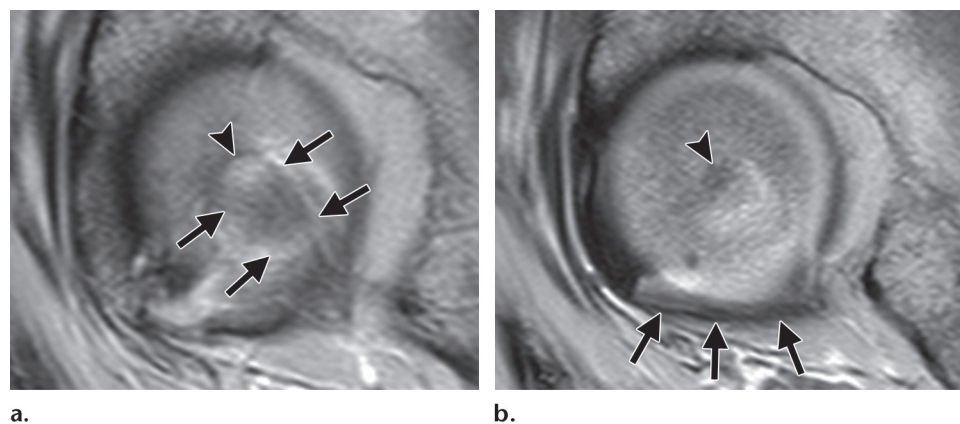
Consecutive sagittal T1-weighted MR arthrograms show the ligamentum teres (arrows in a), the fovea capitis femoris (arrowhead), and the acetabular transverse ligament (arrows in b).
